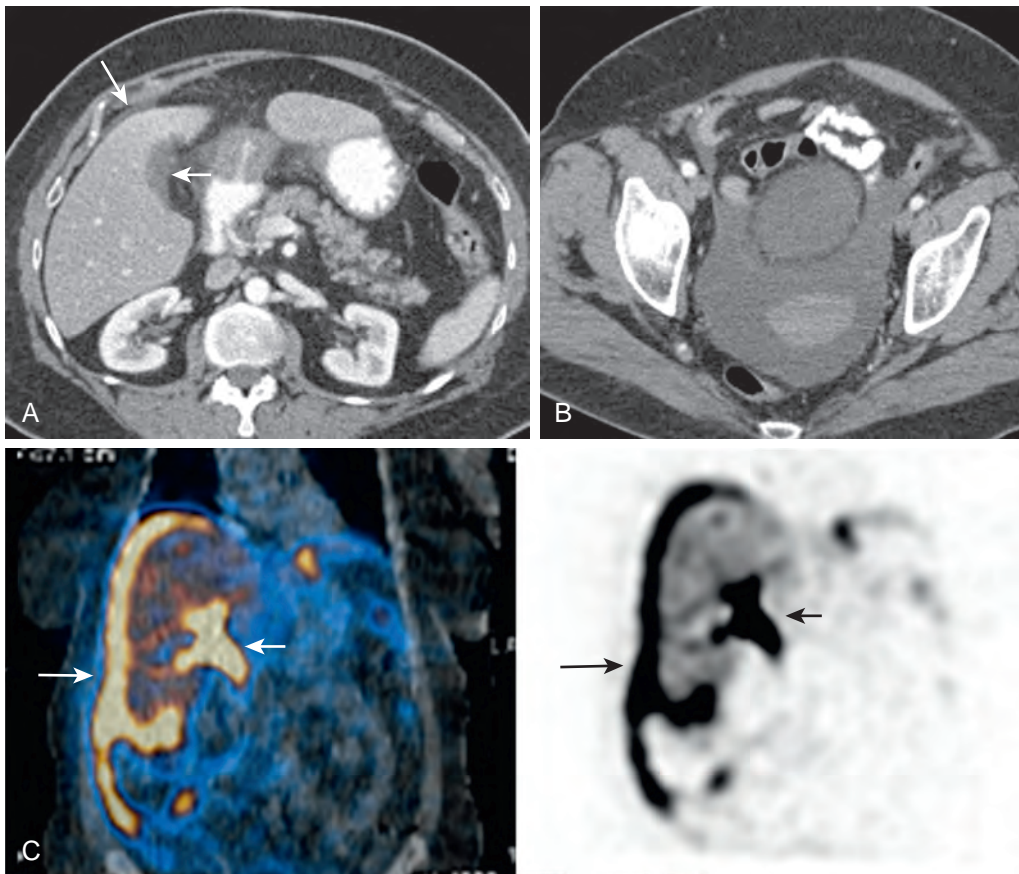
Bile leak confirmed by hepatobiliary scintigraphy. A. CT on second postoperative day after LC in 63-year-old woman with leukocytosis shows minute amount of free fluid around liver (long arrow) and in gallbladder fossa (short arrow); however, a large amount of clear fluid is seen in the pelvis (B). C. ^{99m}Tc -labeled iminodiacetic acid (HIDA) by single photon emission computed tomography (SPECT) on twelfth postoperative day shows active extravasation of radiotracer in the gallbladder fossa (short arrow) and biliary ascites around liver and in right paracolic gutter (long arrow).
